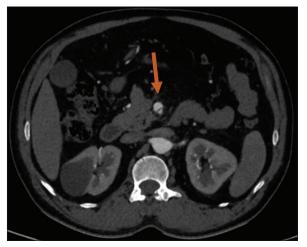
Axial contrast-enhanced computed tomography abdomen shows dissection of superior mesenteric artery into true and false lumen
